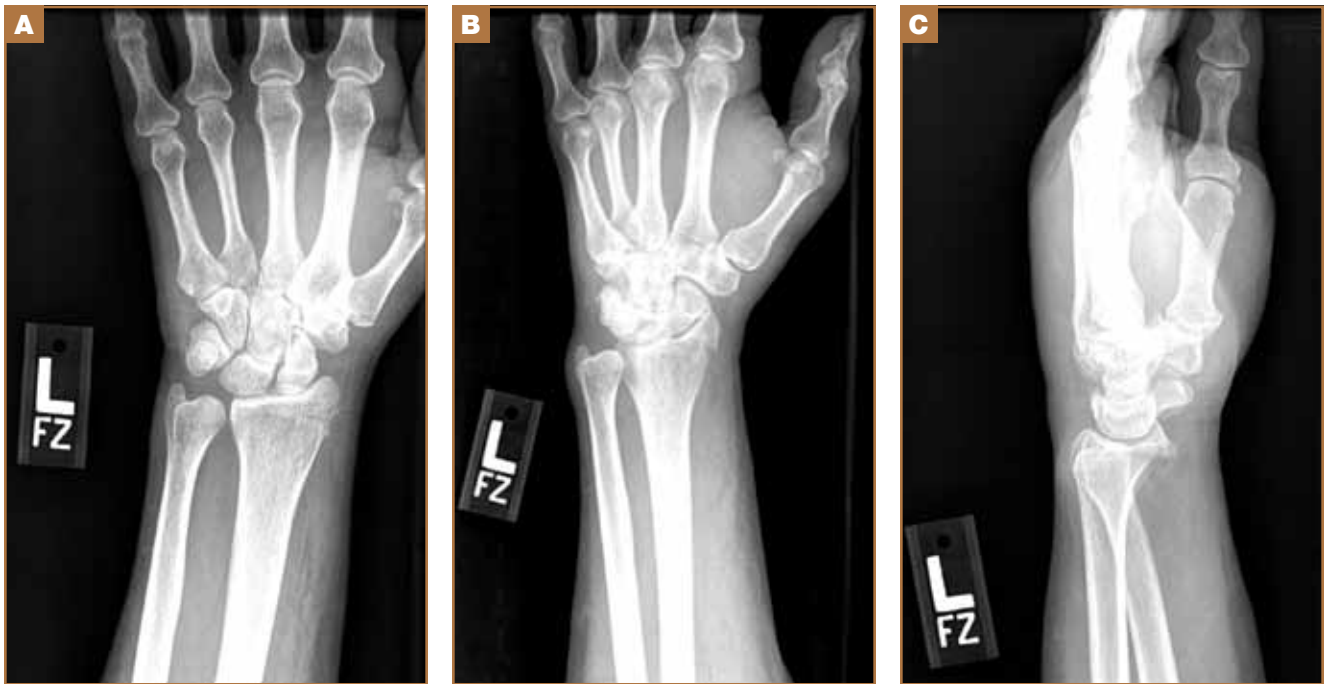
Posteroanterior (A), oblique (B), and lateral (C) view radiographs of the distal radius showing scaphoid fossa displacement and palmar displacement.
